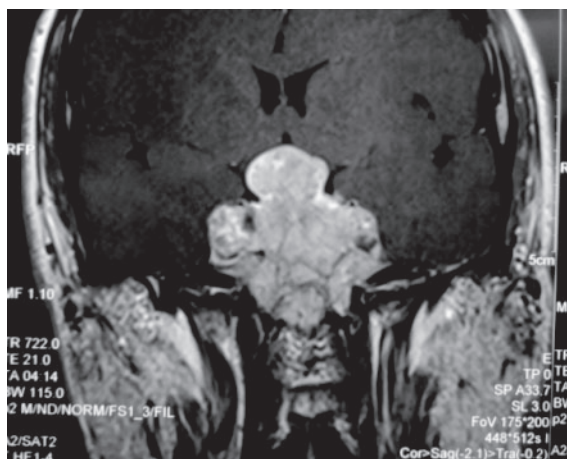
MRI coronal section with a macroprolactinoma showing a hyperintense signal on T1 after the administration of paramagnetic contrast.
